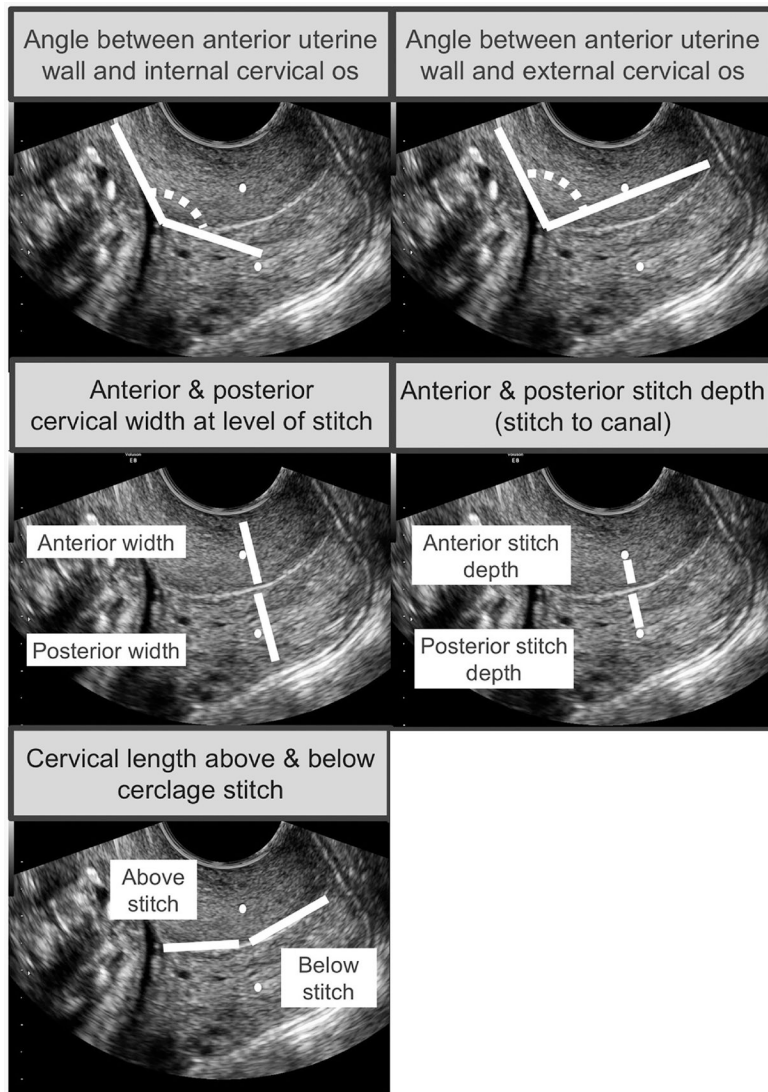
Transvaginal ultrasound parameter measurements. Other parameters assessed included the presence of intra-amniotic sludge, presence of funneling membranes at the level of the internal cervical os, and presence of funneling membranes to or past the level of the cerclage stitch.
